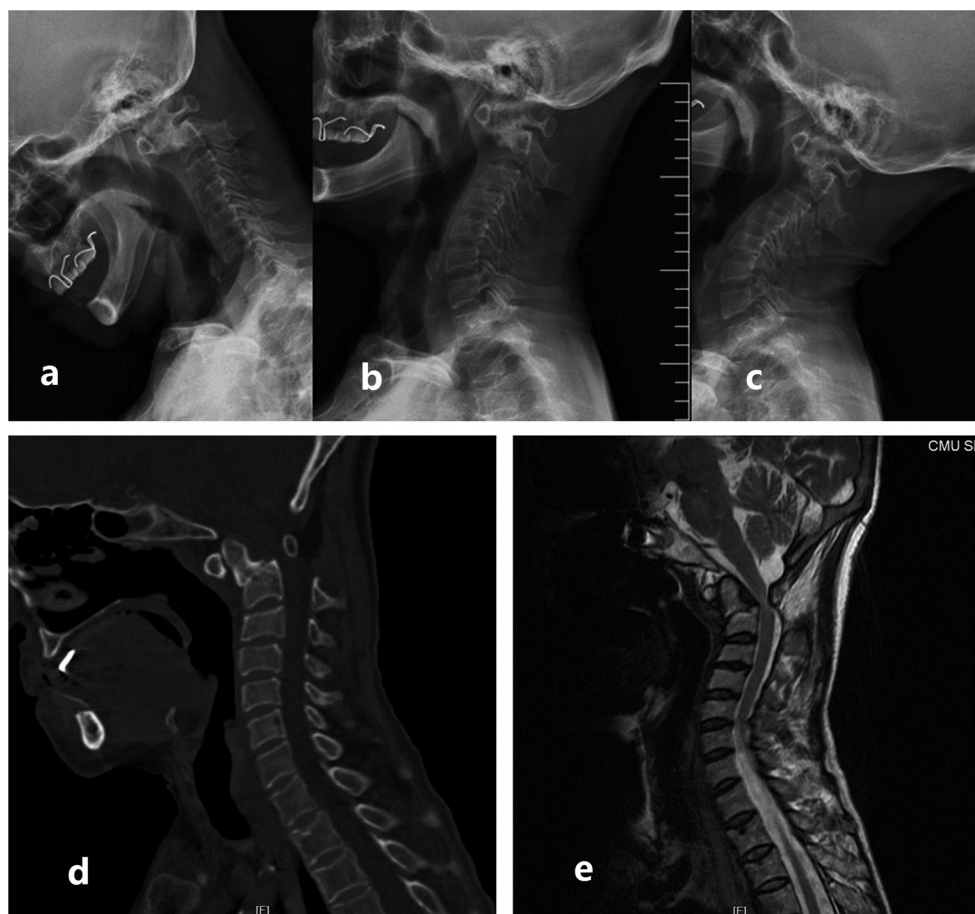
A 53-year-old woman who had progressive symptoms with a stiff limb and unsteady gait was admitted. Odontoid fracture malunion on CT (d), irreducible atlantoaxial dislocation on dynamic DR (a–c) and spinal cord compression on MRI (e) were observed
